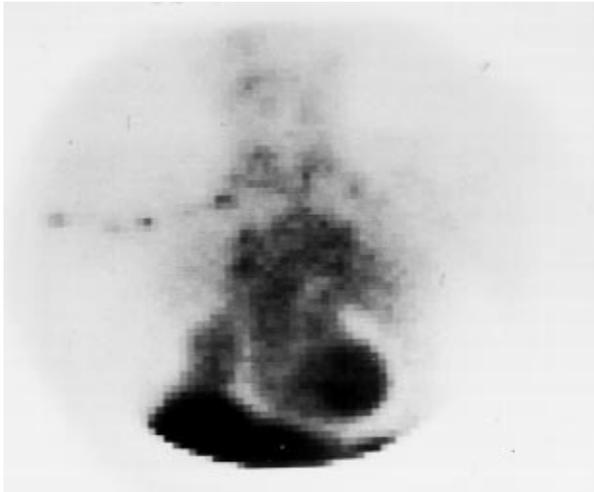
Forty-nine-year-old woman with small cell carcinoma of the lung. A- First phase of the dynamic study reveals that tumor perfusion is in the same phase as the systemic flow (between arrowheads). B- 2-3 min. added frame of the same study reveals increased ^{99m}Tc -MIBI uptake in the lower part of the right lung and pericardial hypoactivity due to pericardial effusion. C-CT scan of the patient demonstrates the tumor in the posterior region of the right lung with atelectasis in the anterior region.
